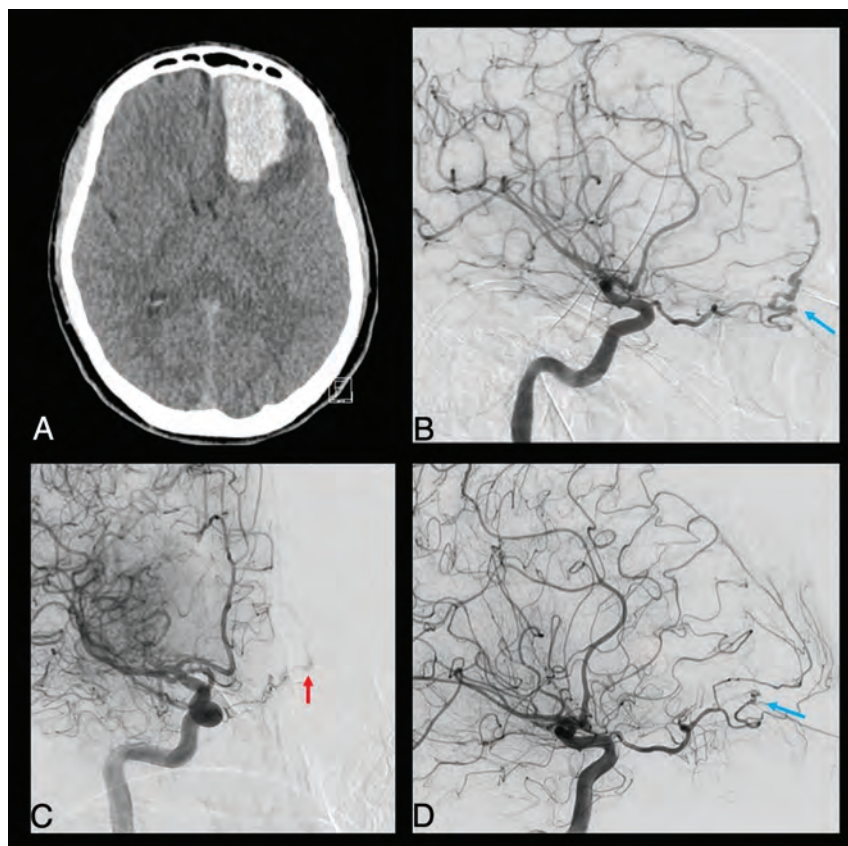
Clinical case of a ruptured cribriform plate dAVF. A 49-year-old man was admitted for sudden onset of unusual headache with nausea and vomiting. The CT scan performed in the emergency department (A) shows a left frontal basis intraparenchymal hematoma. The DSA highlighted a cribriform plate dAVF with major feeders represented by the left anterior ethmoidal artery from the left OA (blue arrow in B). The right ICA injection also showed a contribution from the contralateral OA through its ethmoidal branches (red arrow in C). The venous drainage was represented by a single cortical vein directed into the superior sagittal sinus (type III according to the Cognard-Lariboisière classification²⁶). The patient successfully underwent left supraorbital craniotomy and clipping of the dAVF (D), with no enhancement of the dAVF on the postoperative DSA (blue arrow) and complete clinical recovery.
